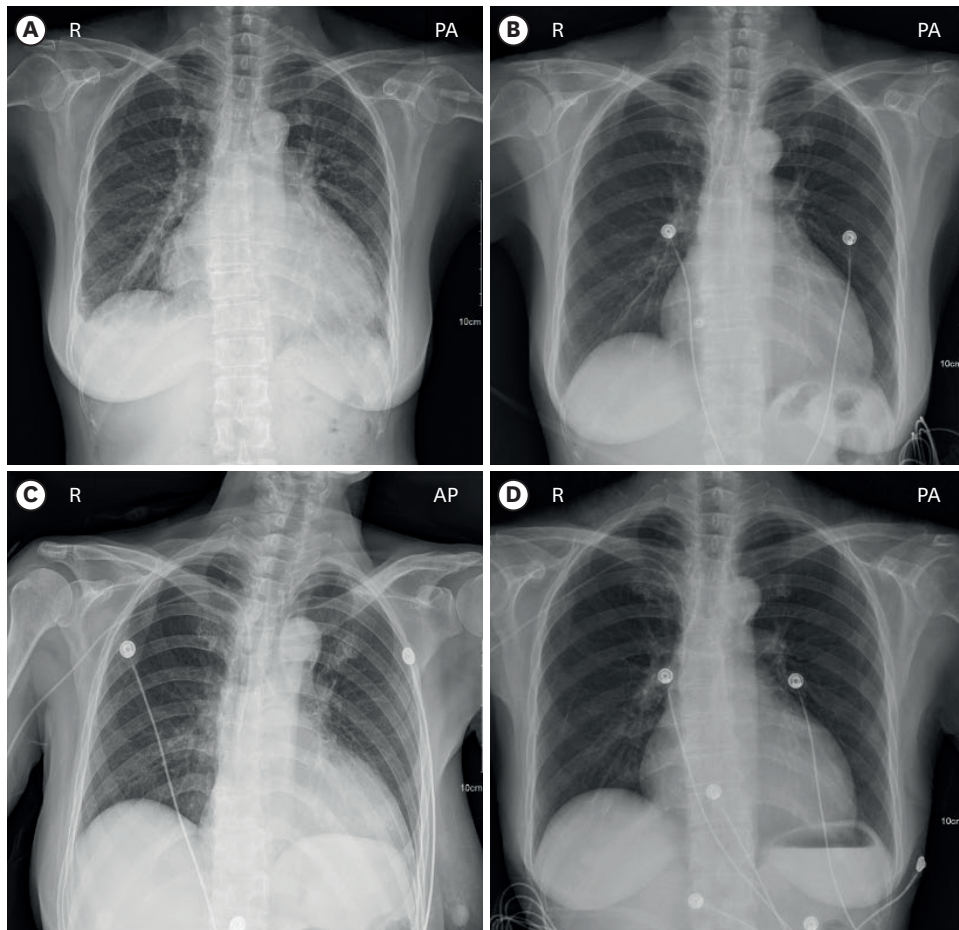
Change in chest radiography. (A) At the time of referral, (B) during initial decongestive response, (C) at the time of recurrent congestion, and (D) after acetazolamide initiation and achievement of clinical euvolemia before heart transplantation. R = right; PA = posteroanterior view; AP = anteroposterior view.
